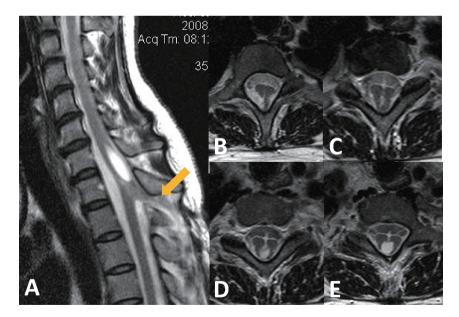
Cervicothoracic spine Magnetic Resonance Imaging (MRI) T2 weighted image (T2WI) demonstrates a DST (sagittal image; A, axial image; B-E)
